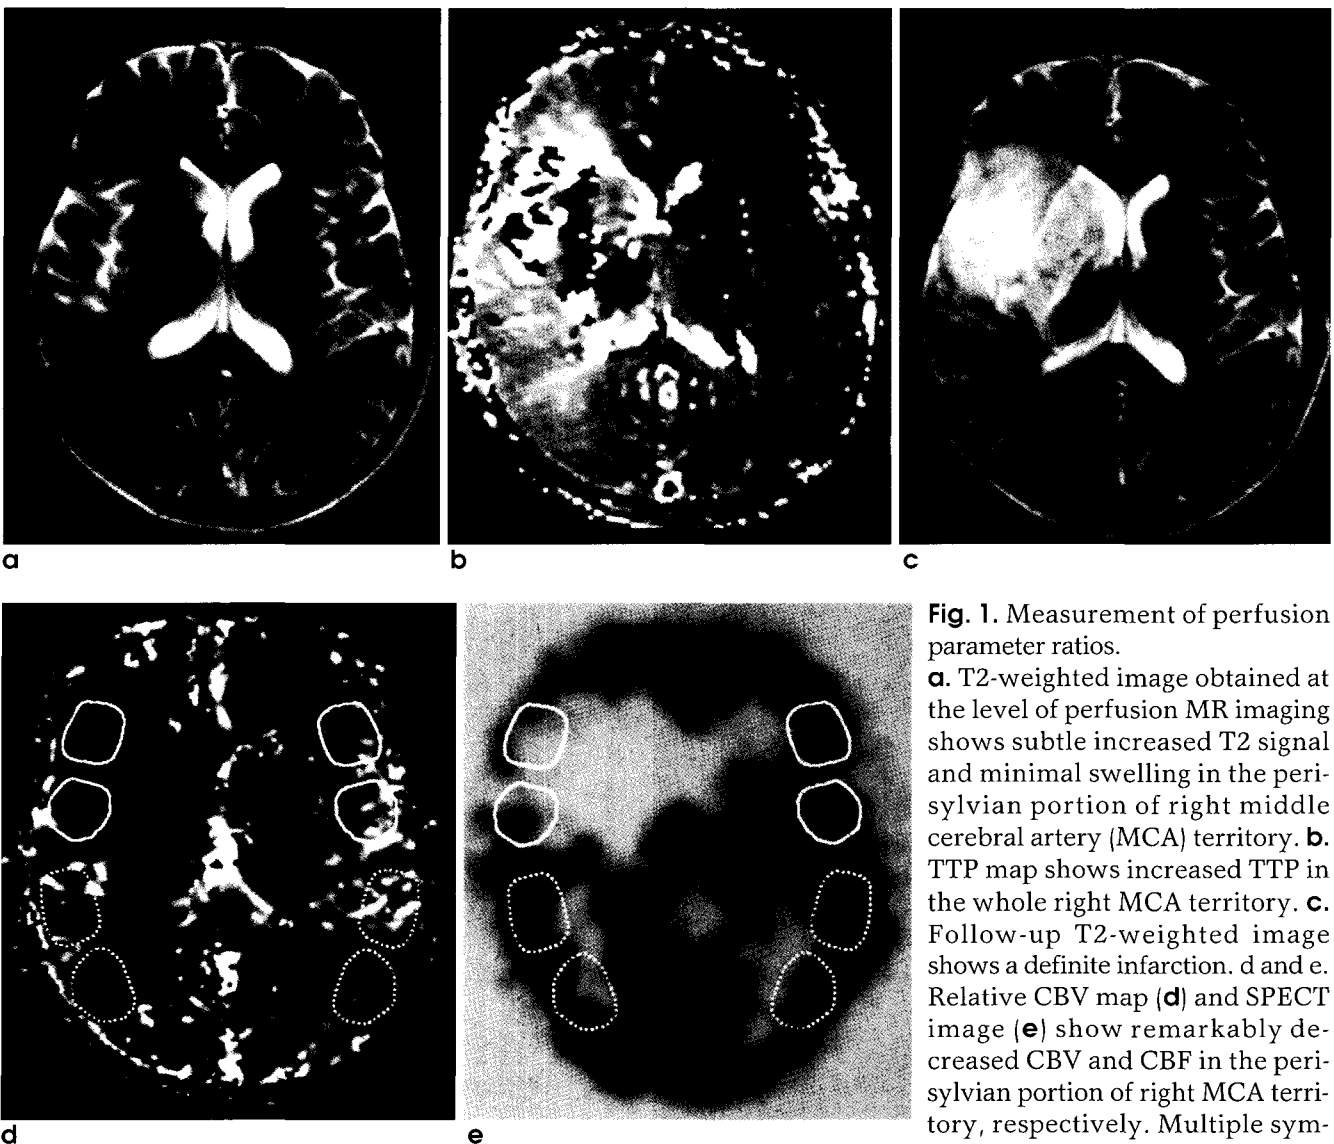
Measurement of perfusion parameter ratios. a. T2-weighted image obtained at the level of perfusion MR imaging shows subtle increased T2 signal and minimal swelling in the perisylvian portion of right middle cerebral artery (MCA) territory. b. TTP map shows increased TTP in the whole right MCA territory. c. Follow-up T2-weighted image shows a definite infarction. d and e. Relative CBV map (d) and SPECT image (e) show remarkably decreased CBV and CBF in the perisylvian portion of right MCA territory, respectively. Multiple symmetrical ROIs are placed in regions with evolving infarction (solid line in right hemisphere) and without evolving infarction (dotted line in left hemisphere) for measurement of relative CBV and CBF ratios.
